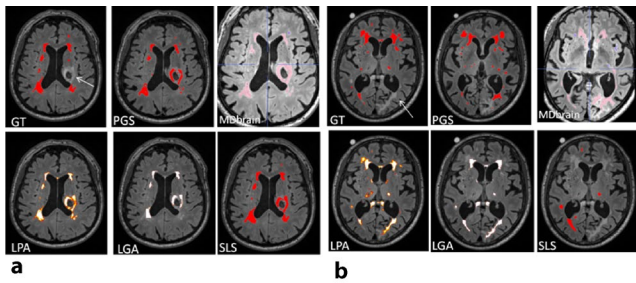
208 WMH segmentation performance of different tools falsely detecting FLAIR hyperintense „WMH mimics“ surrounding large hemorrhages (a) or post-hemorrhagic hyperintense changes (b). Pathological hyperintense FLAIR structures are depicted in white arrow in the GT panel
